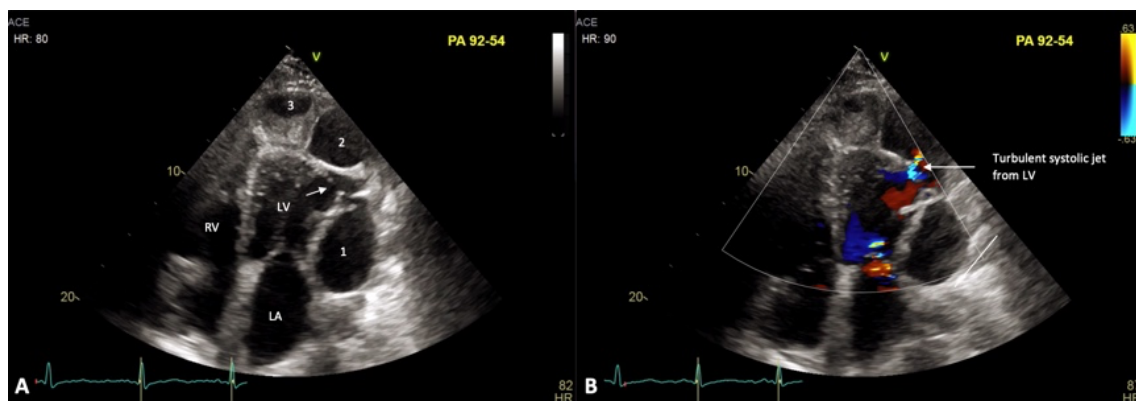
A. 2D transthoracic echocardiography, apical 4-chamber view. LV=left ventricle; LA=left atrium; RV=right ventricle; Numbers 1 to 3 are the multiple locations of the pseudoaneurysm. B. Color-Doppler echocardiography shows the communication with the Ps sac.
